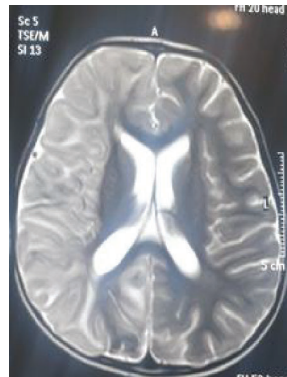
MRI of brain at 25 months of age shown T2 hyperintensity of right hemisphere
